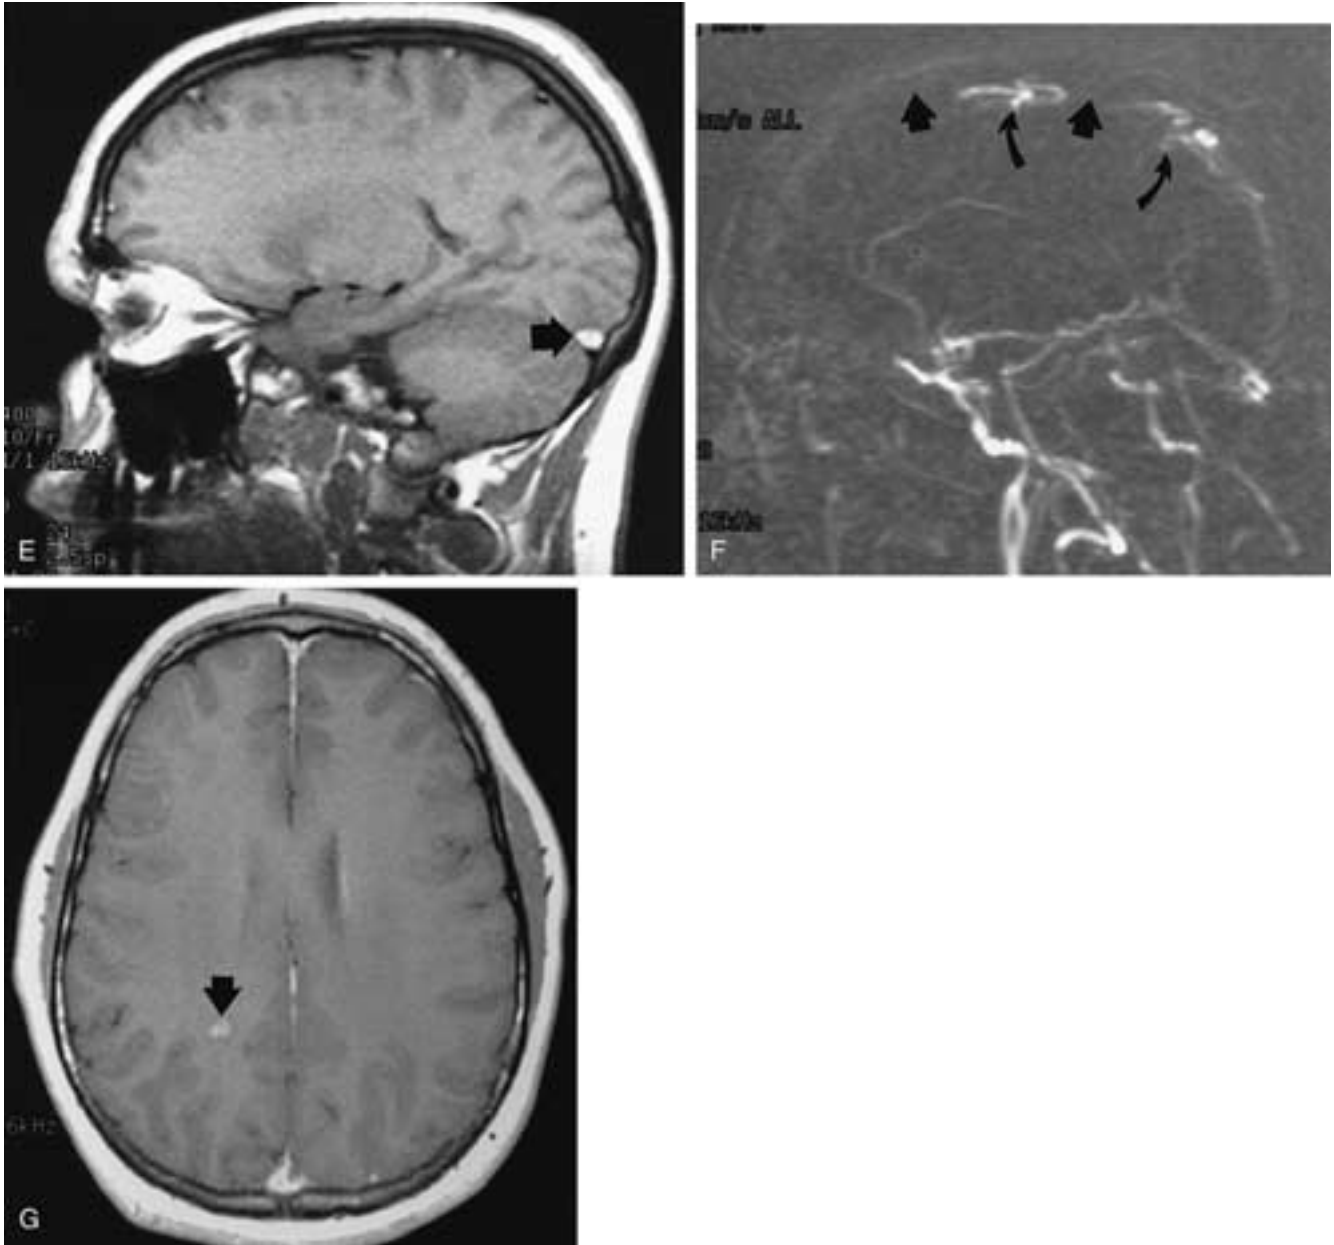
Continued* E, T1-weighted parasagittal image reveals clot (*arrow*) in the transverse sinus (*arrow*). F, 2D phase contrast MR venogram (sagittal) shows nearly complete absence of flow in the superior sagittal sinus (*arrows*), with minimal flow in the cortical veins. G, T1-weighted image after gadolinium enhancement reveals an area of enhancement (*arrow*) in white matter compatible with venous infarction.
